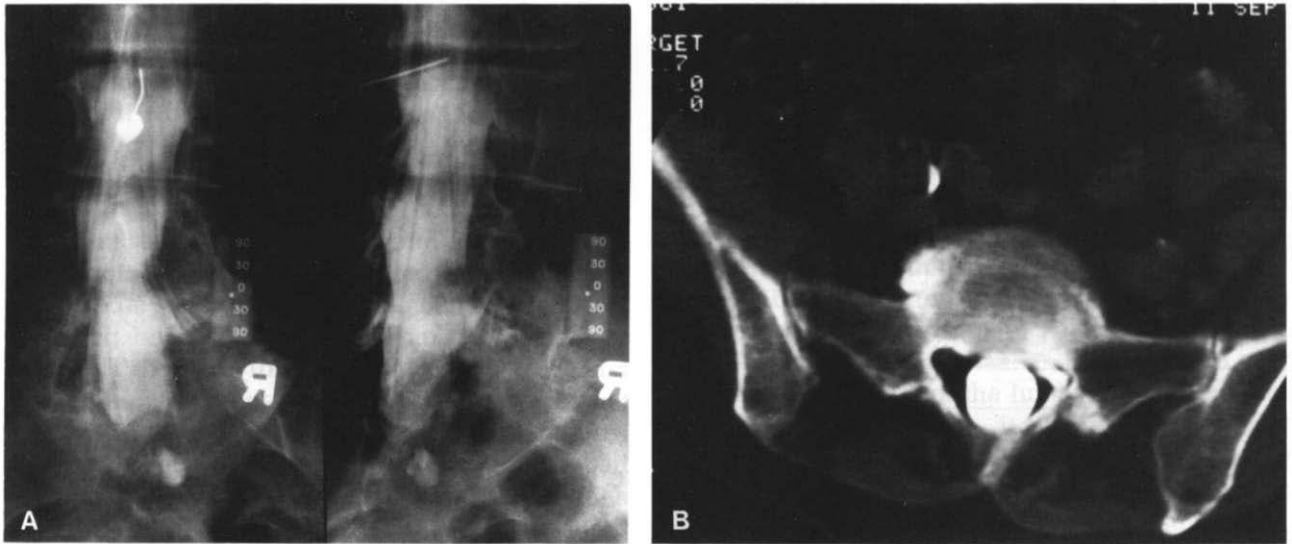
(A) These are the x-rays of an 80-year-old patient with severe sciatica unrelied by several weeks of bed rest and not accentuated by the straight leg raising test (negative SLR test). There is an anteroposterior and an oblique view. Both show the two nerve roots entering the L5–S1 intervertebral foramen. Note relative radiolucency of contrast just at the entrance of the foramen, seen best on the oblique view. (B) It is interesting to note on this CT with contrast that with double roots entering the L5–S1 intervertebral foramen on the right, there is an associated absence of the S2 nerve root on the right in the upper portion of the sacral canal.
